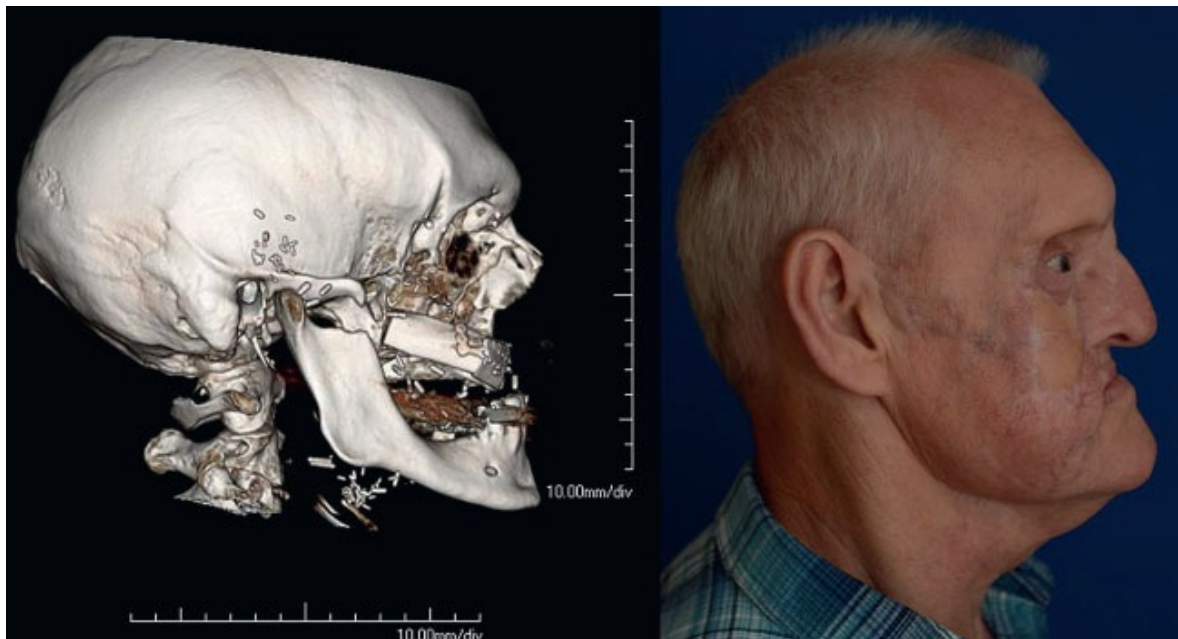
• Postoperative CT and photograph of the patient in FIG 5. CT image shows that the operation has been performed according to the virtual plan, resulting in successful restoration of midface contour.
